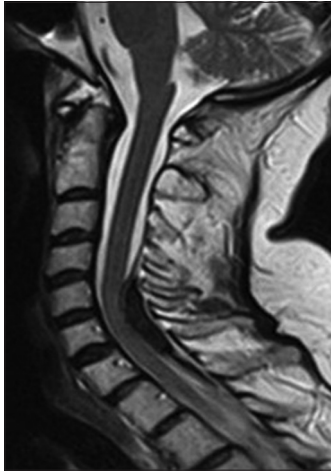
This figure shows a T2W MRI midsagittal section of the c-spine in which a posteriorly originating hypointense epidural collection is seen suggesting a hyperacute epidural hematoma.
